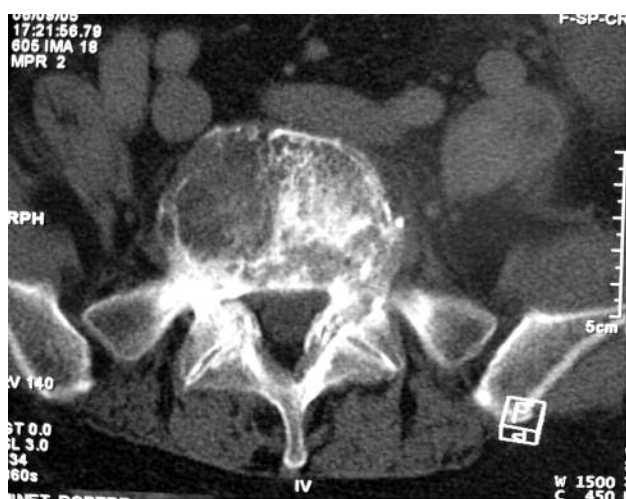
Pre-op CT scan after 5 cycles of polychemotherapy: disappearance of the extension to the muscles, shrinkage of the mass and beginning of bone reconstruction.
